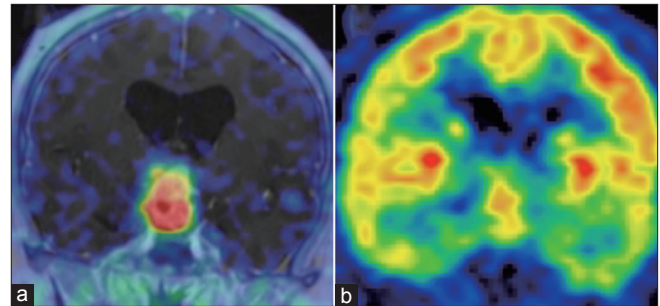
Both ^{11}C -MeAIB PET (a) and ^{18}F -FDG PET (b) show high accumulation in the suprasellar lesion
